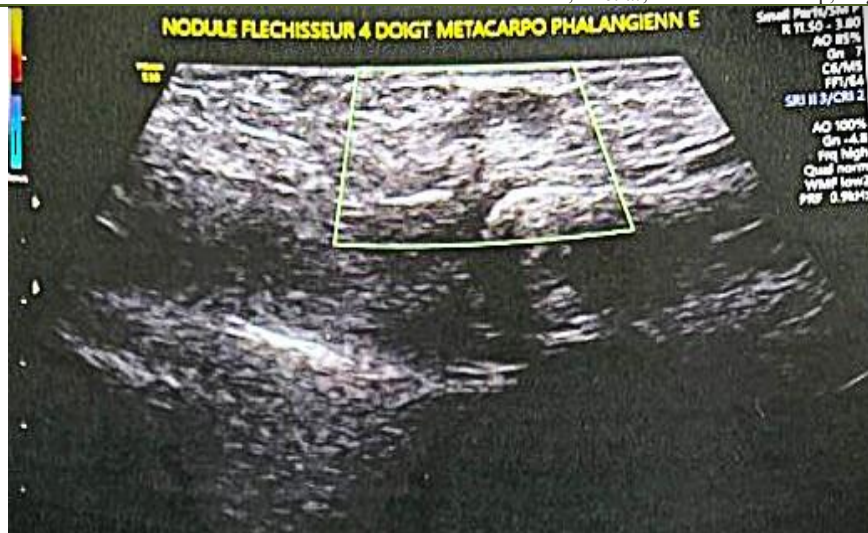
Color Doppler imaging demonstrating no vascularity within the lesion
